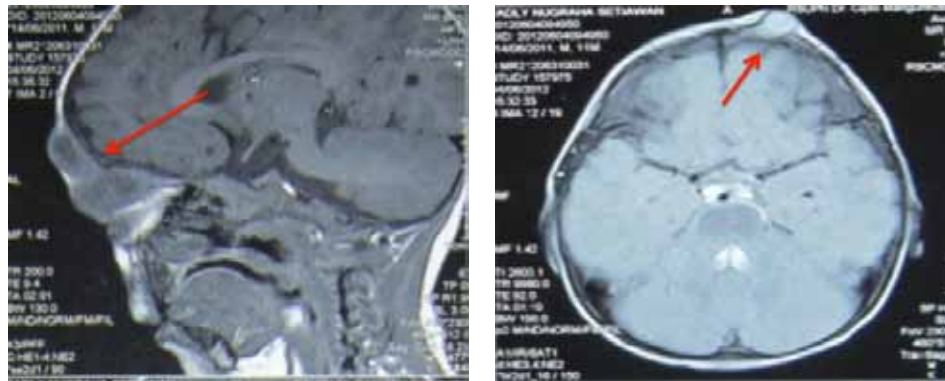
(a): MRI demonstrating frontal-nasal abscess. (b): Frontonasal abscess was related with the upper eyelid abscess of LE.
